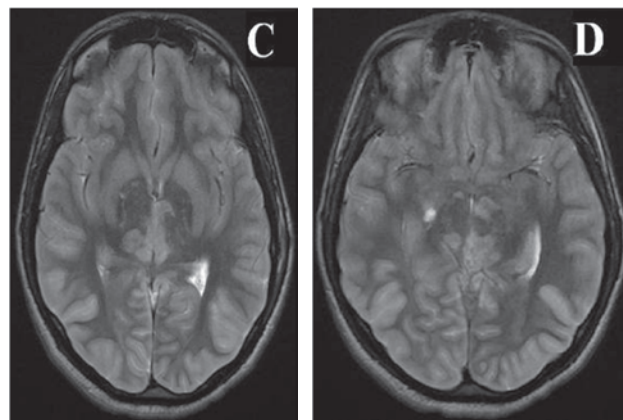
C & D: MRI brain (T2-weighted sequence) of the same patient showing diffusely increased signal, consistent with hypoxic-ischemic brain damage.
